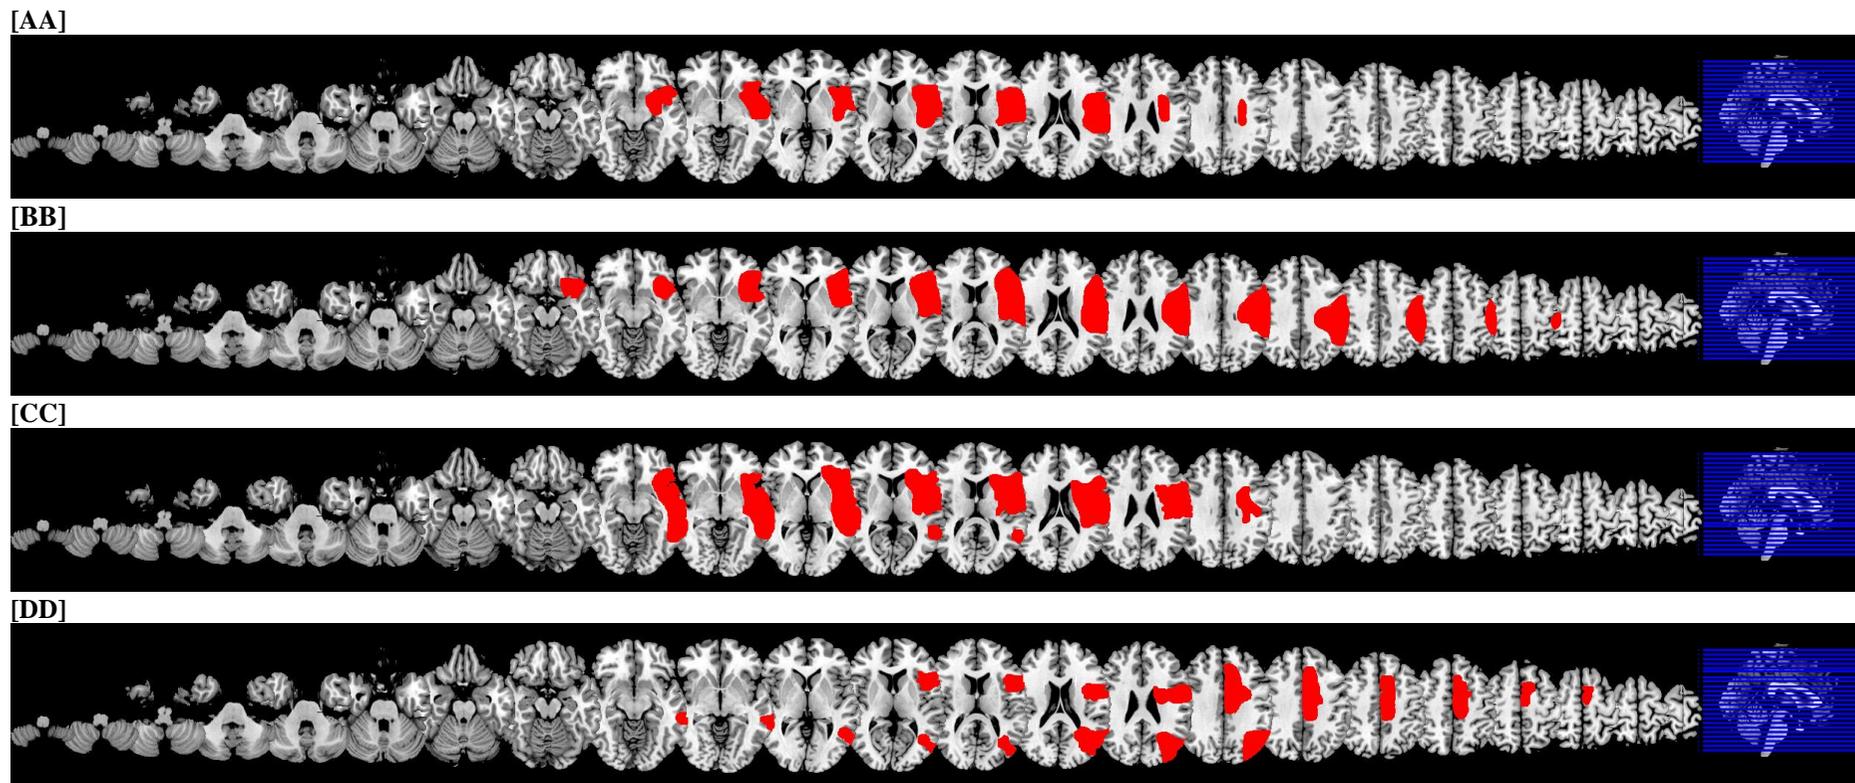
Participant's lesion maps. MRI and CT scans were reviewed by a neurologist (T.C.) who delineated lesion boundaries. Lesion regions were then mapped using MRICron (Rorden et al., 2007) ch2bet.nii template and multislice views were created using axial slices, $z=$ 14,20,26,32,38,44,50,56,62,68,74,80,86,92,98,104,110,116,122,128,134,140,146. All lesions have been flipped to the right hemisphere. A sagittal slices for visualization are provided on the far right.
